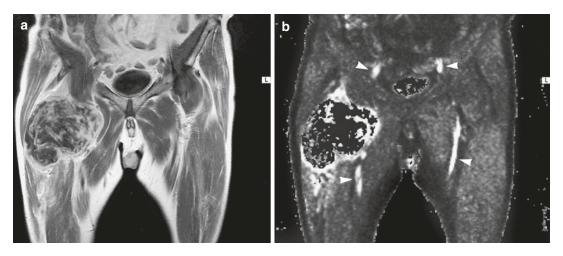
(a, b) Monitoring chemotherapy with first-pass images. (a) The coronal contrast-enhanced T1-weighted image shows inhomogeneous enhancement in a large myxofibrosarcoma after two cycles of chemotherapy. The degree of response cannot be assessed on the spin-echo
